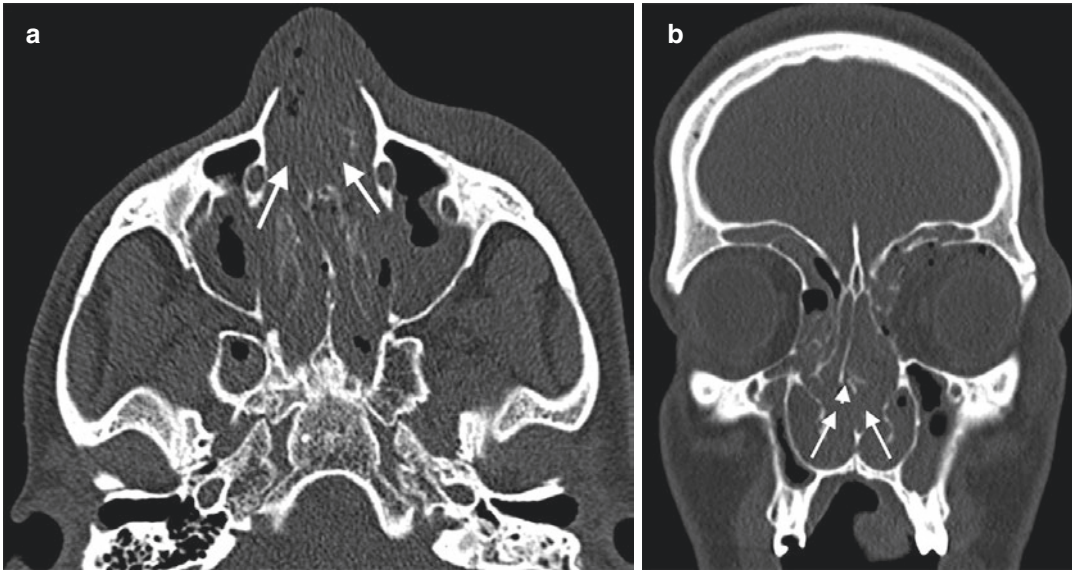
Septal hematoma in a 21-year-old man after MVA. Axial (a) and coronal (b) CT images reveal abundant hemorrhage (arrows) resulted from nasal fracture
